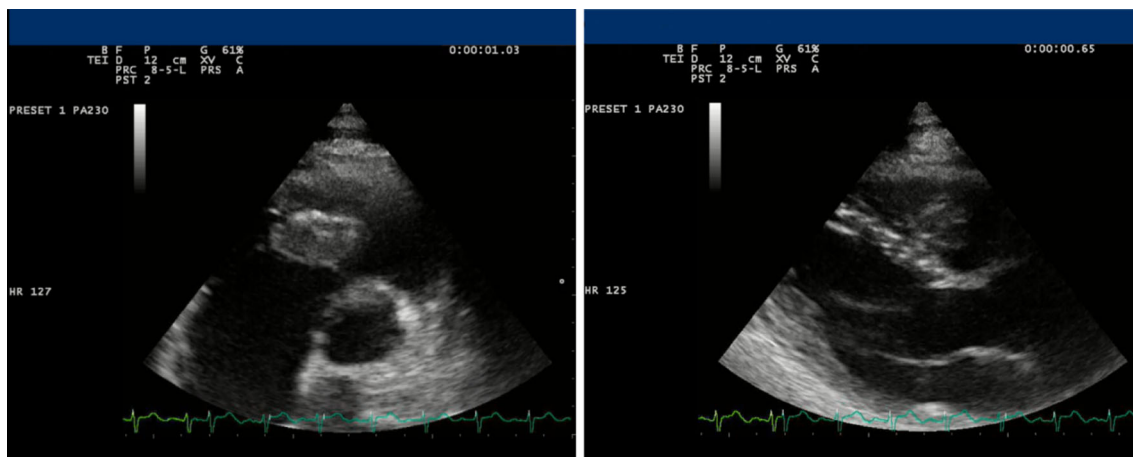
Transthoracic echocardiogram (TTE) views before surgery showing a right ventricular mass (approximately 3 × 2 cm) attached to the interventricular septum by a small pedicle and dilated right heart chambers
